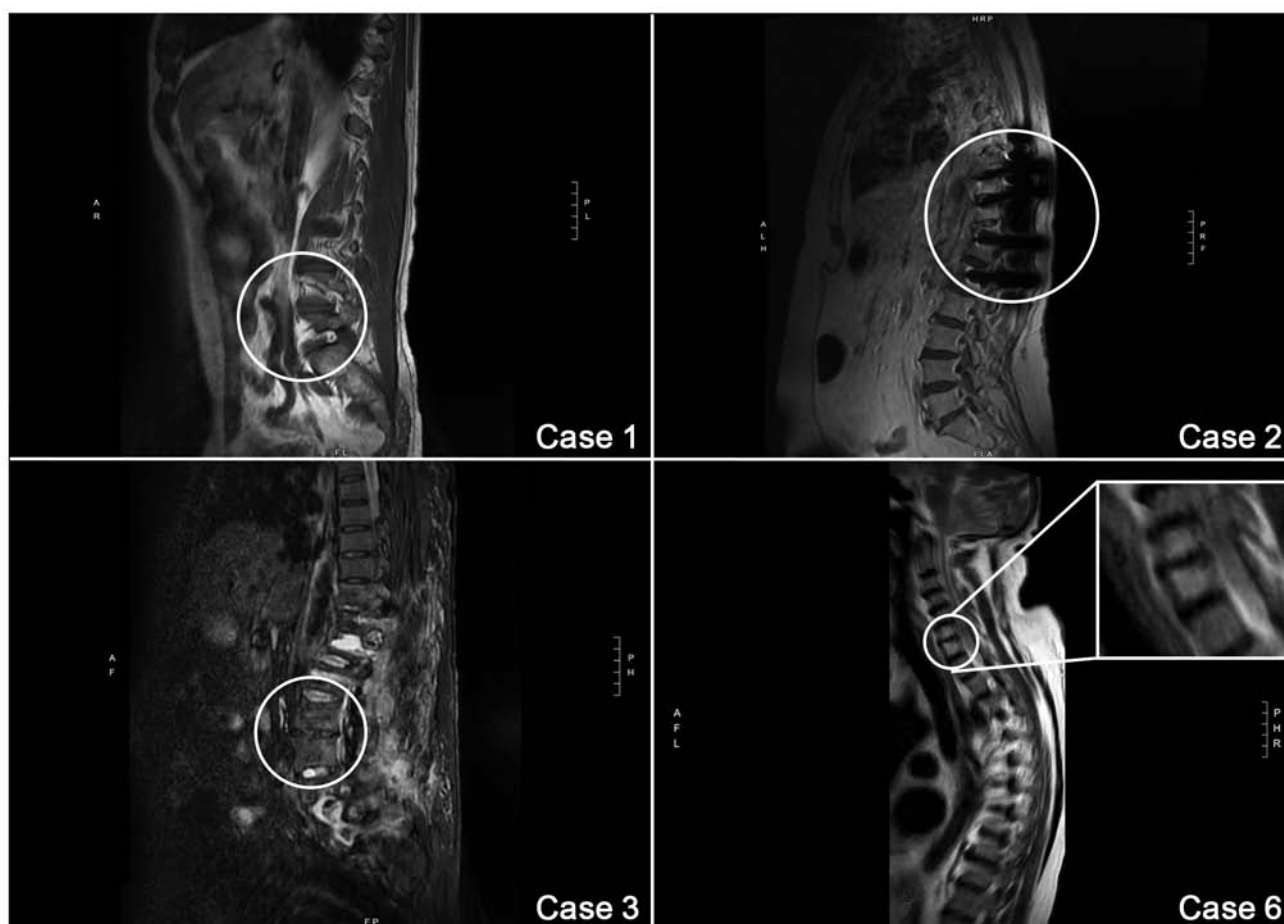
This four-panel figure presents the MRI results upon admission of the patients in cases 1, 2, 3 and 6. An MRI for cases 4 and 5 was performed at external facilities prior to admission to the authors' unit. Case 1: D7-D8 spondylitis with a collection of fluids inside the spinal canal (D4-D8); case 2: Inflammatory lesions at D8-D9 level, compatible with spondylodiscitis by superinfection; case 3: Subfascial and paravertebral fluid collection going from L4 to L5, also flanking the metallic bone fixators from D12 to S1; case 6: Fluid collections in the anterior epidural intra-rachides and in the left paramedian paravertebral tissues.
